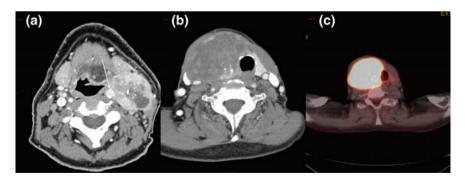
Thyroid cancer. a Contrast-enhanced CT. b Contrast-enhanced CT. c PET-CT. In (a) there is a conglomerate nodal mass involving multiple left cervical nodes in a patient with known metastatic papillary thyroid cancer. Notice partial encasement of the left carotid artery (*arrow*) less than 180°. In (b) and (c) there is large, heterogeneously enhancing mass of the right thyroid lobe with tracheal deviation. This anaplastic thyroid cancer lesion is FDG avid as shown in 5.18c
